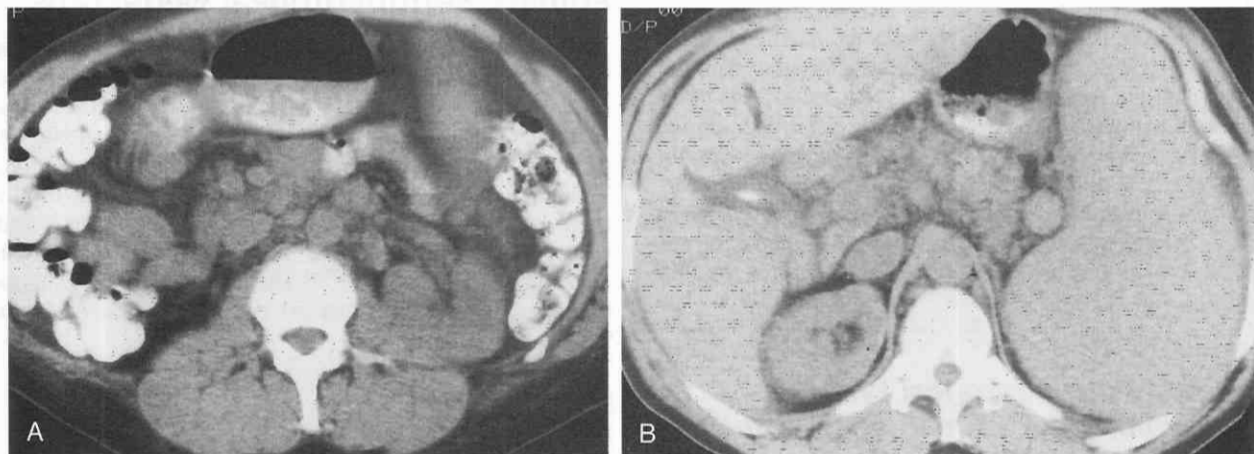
Retroperitoneal lymph node enlargement in a 41-year-old patient with sarcoidosis. *A*, Unenhanced CT image demonstrates multiple, mildly enlarged lymph nodes in the para-aortic region of the retroperitoneum. *B*, CT image at the upper abdomen level reveals a massively enlarged spleen and several mildly enlarged retrocrural lymph nodes. All of these abnormalities are a result of sarcoidosis.
